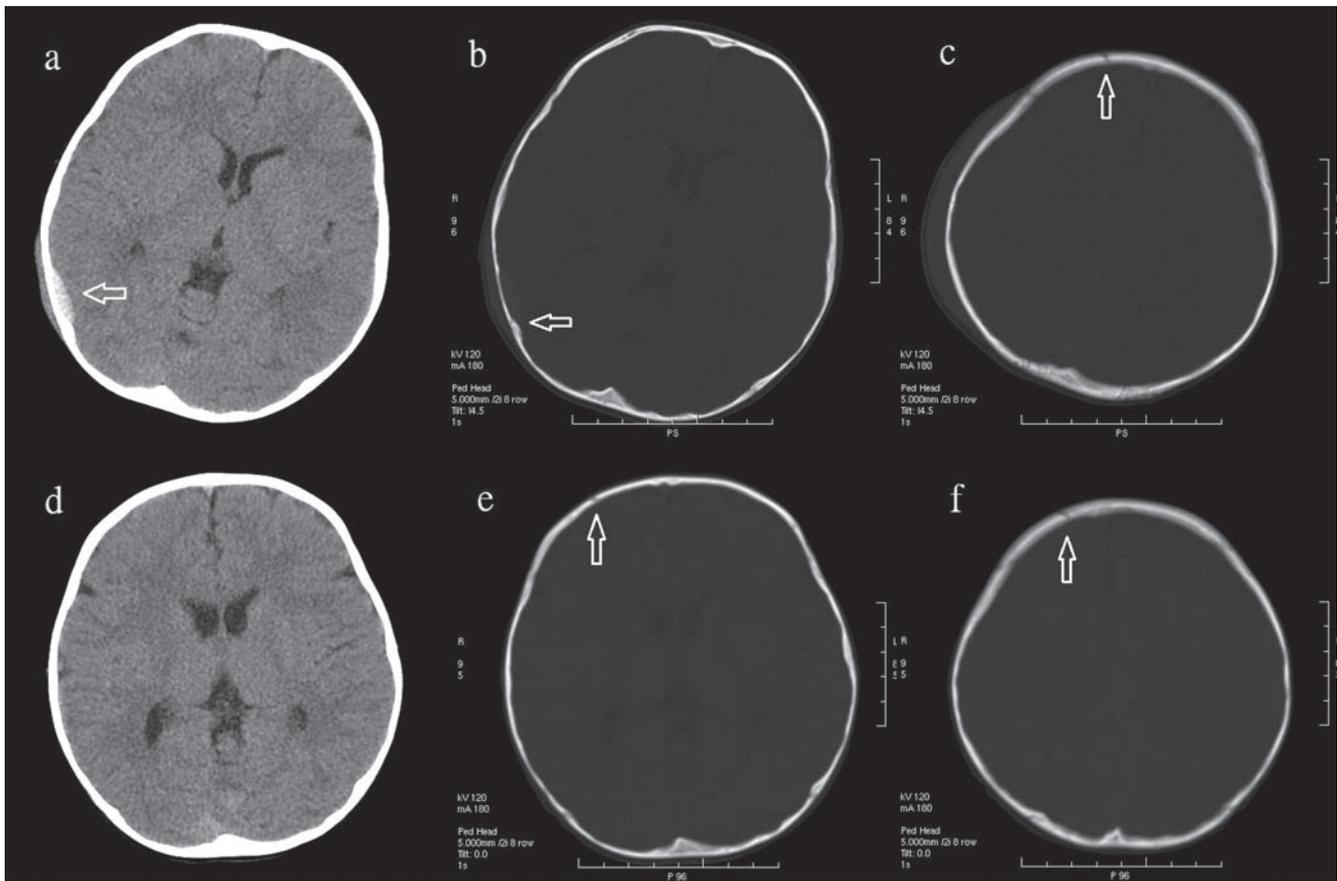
Non-contrast axial CT scan of a two-year-old boy in brain and bone windows, immediately after injury to the right parietal region of the head (a-c) and three months after injury (d-f). (a) A small epidural haematoma is noted (arrow), together with scalp swelling over the parietal region. (b) A subtle hair-line fracture at the parietal bone is noted at bone window (arrow). (c) Axial image at a higher level shows another more obvious lucent line at the right frontal bone (arrow), highly suspicious of a second fracture. (d) Three months later, the right parietal epidural haematoma and scalp swelling have completely resolved. Bone window (e) also showed healing of the right parietal bone fracture. However, a persistent lucent line is still seen tracking along the right frontal bone (arrows in e and f).
